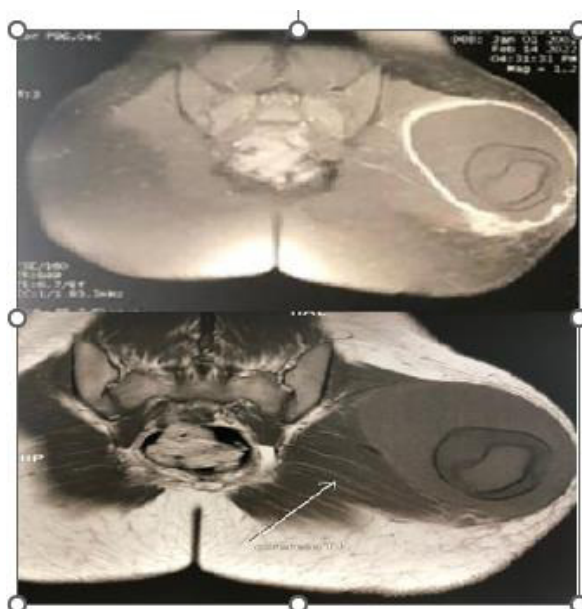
MRI images showing the constitution of the cyst and its envelope.
